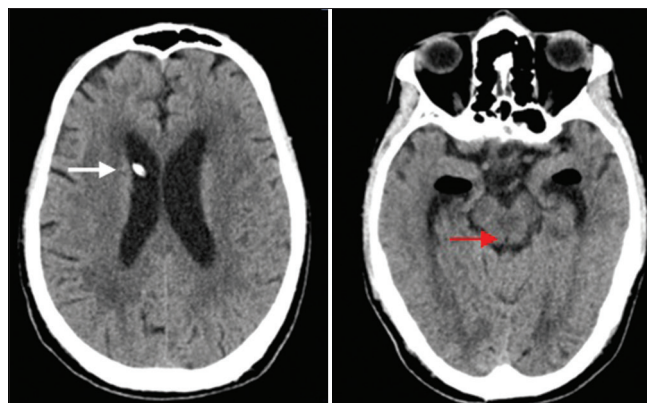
Computed tomography on day 4 of admission shows resolution of hydrocephalus and the external ventricular drain is seen in the frontal horn of right lateral ventricle (white arrow) (left). The blood clot has cleared and the aqueduct of Sylvius now appears hypodense (red arrow) (right)
